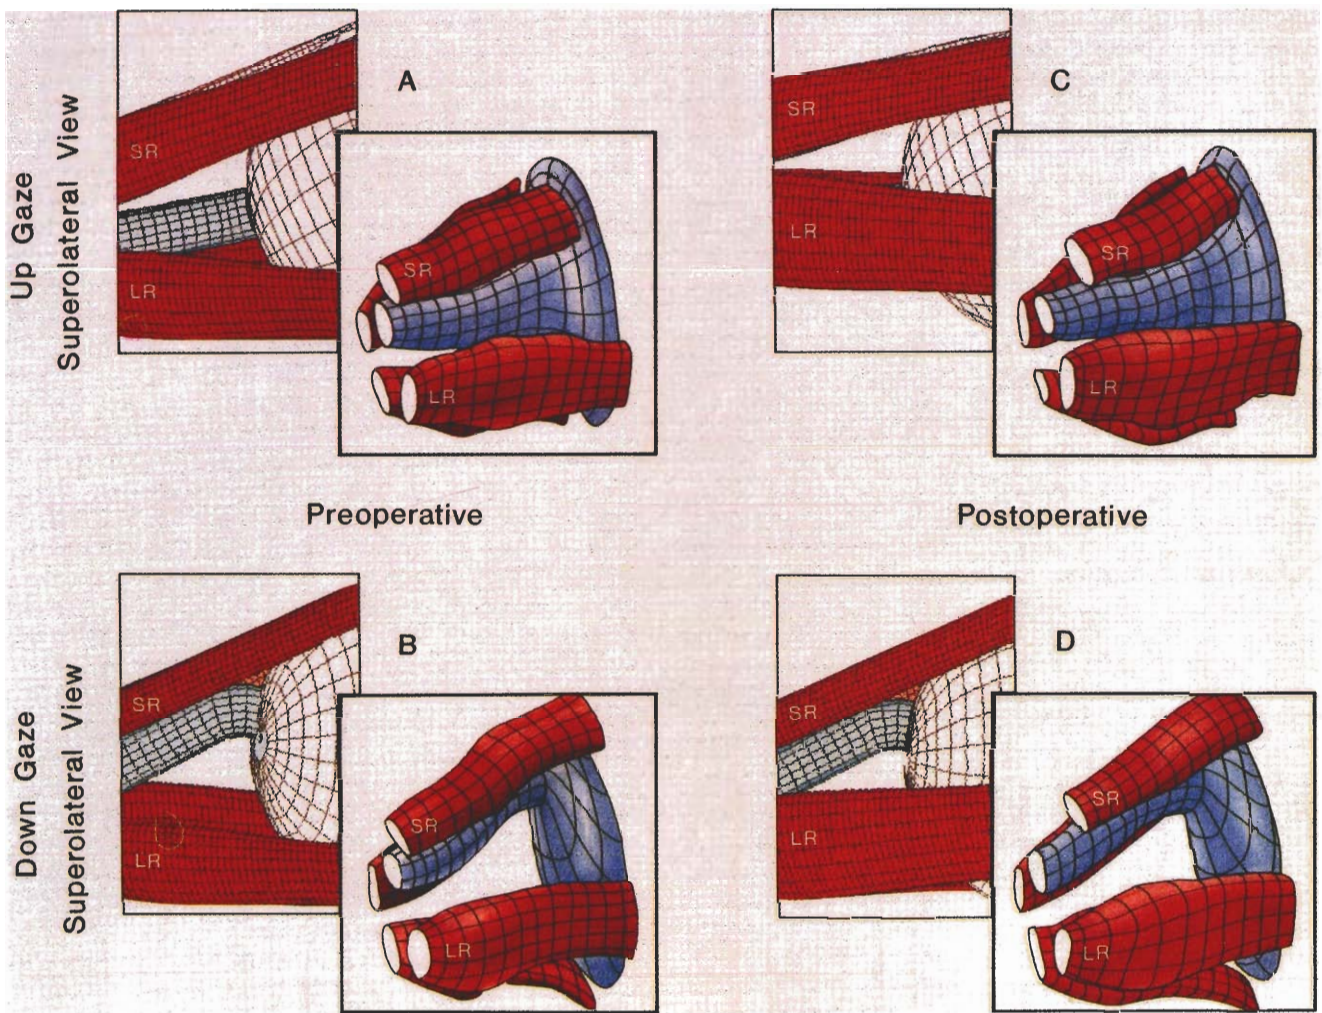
Case 5. Three-dimensional magnetic resonance imaging orbital reconstructions. Format as in Figure 5. A, superolateral view of the preoperative right eye in upgaze. B, superolateral view of the preoperative right eye in downgaze. C, superolateral view of the postoperative right eye in upgaze. D, superolateral view of the postoperative right eye in downgaze.
